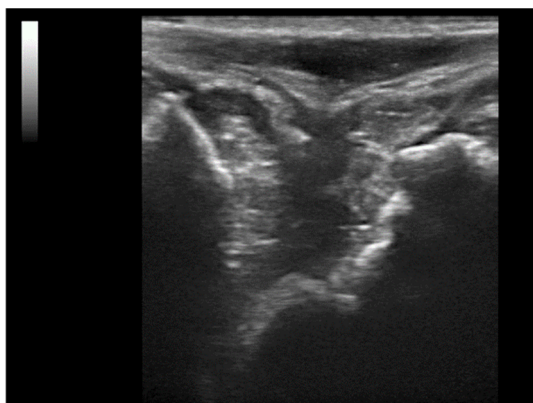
Peroneus tendon sheath filled with heterogeneous material and marked irregularities of distal fibular bone cortical. Ultrasound image, short axis.*
